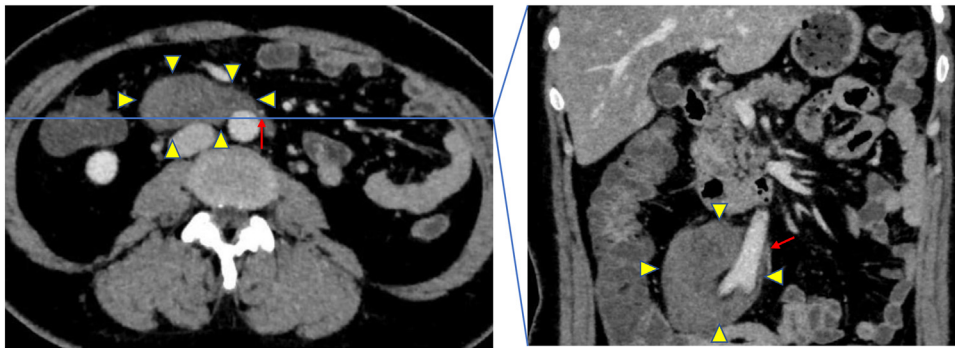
Contrast-enhanced computed tomography (CT) scan showing a 90 mm not-enhanced retroperitoneal tumor (yellow arrowheads), partially located between the aorta and IMA (red arrow).
